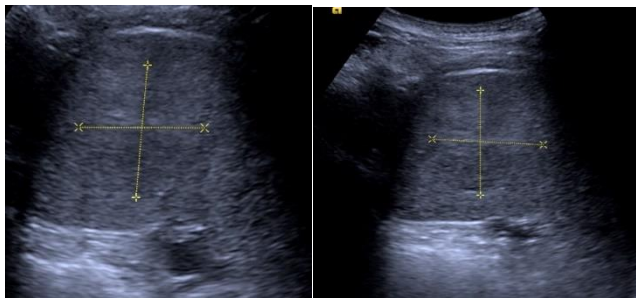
and 1b shows the B-mode sonography examination of the lesion. The lesion has a round nodule configuration, hypoechoic halo sign in the lower lobe of the spleen. The lesion is hypoechoic generally but hyperintense small septations extending from peripherally towards to the center of the lesion which could correspond to the 'spoke-wheel' pattern of the splenic angiomatoid nodular transformation lesion of the spleen.
